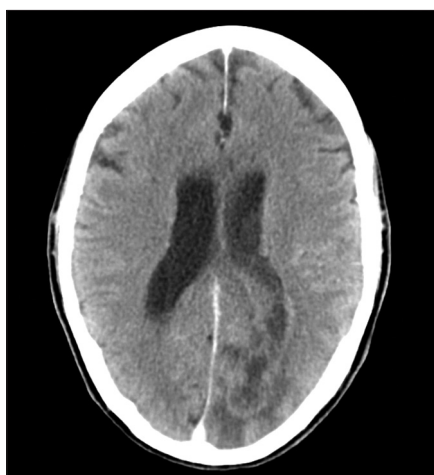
Computed tomography of the head demonstrating a mixed density left occipital lesion with the presence of hypodense material extending into the lateral ventricle.
